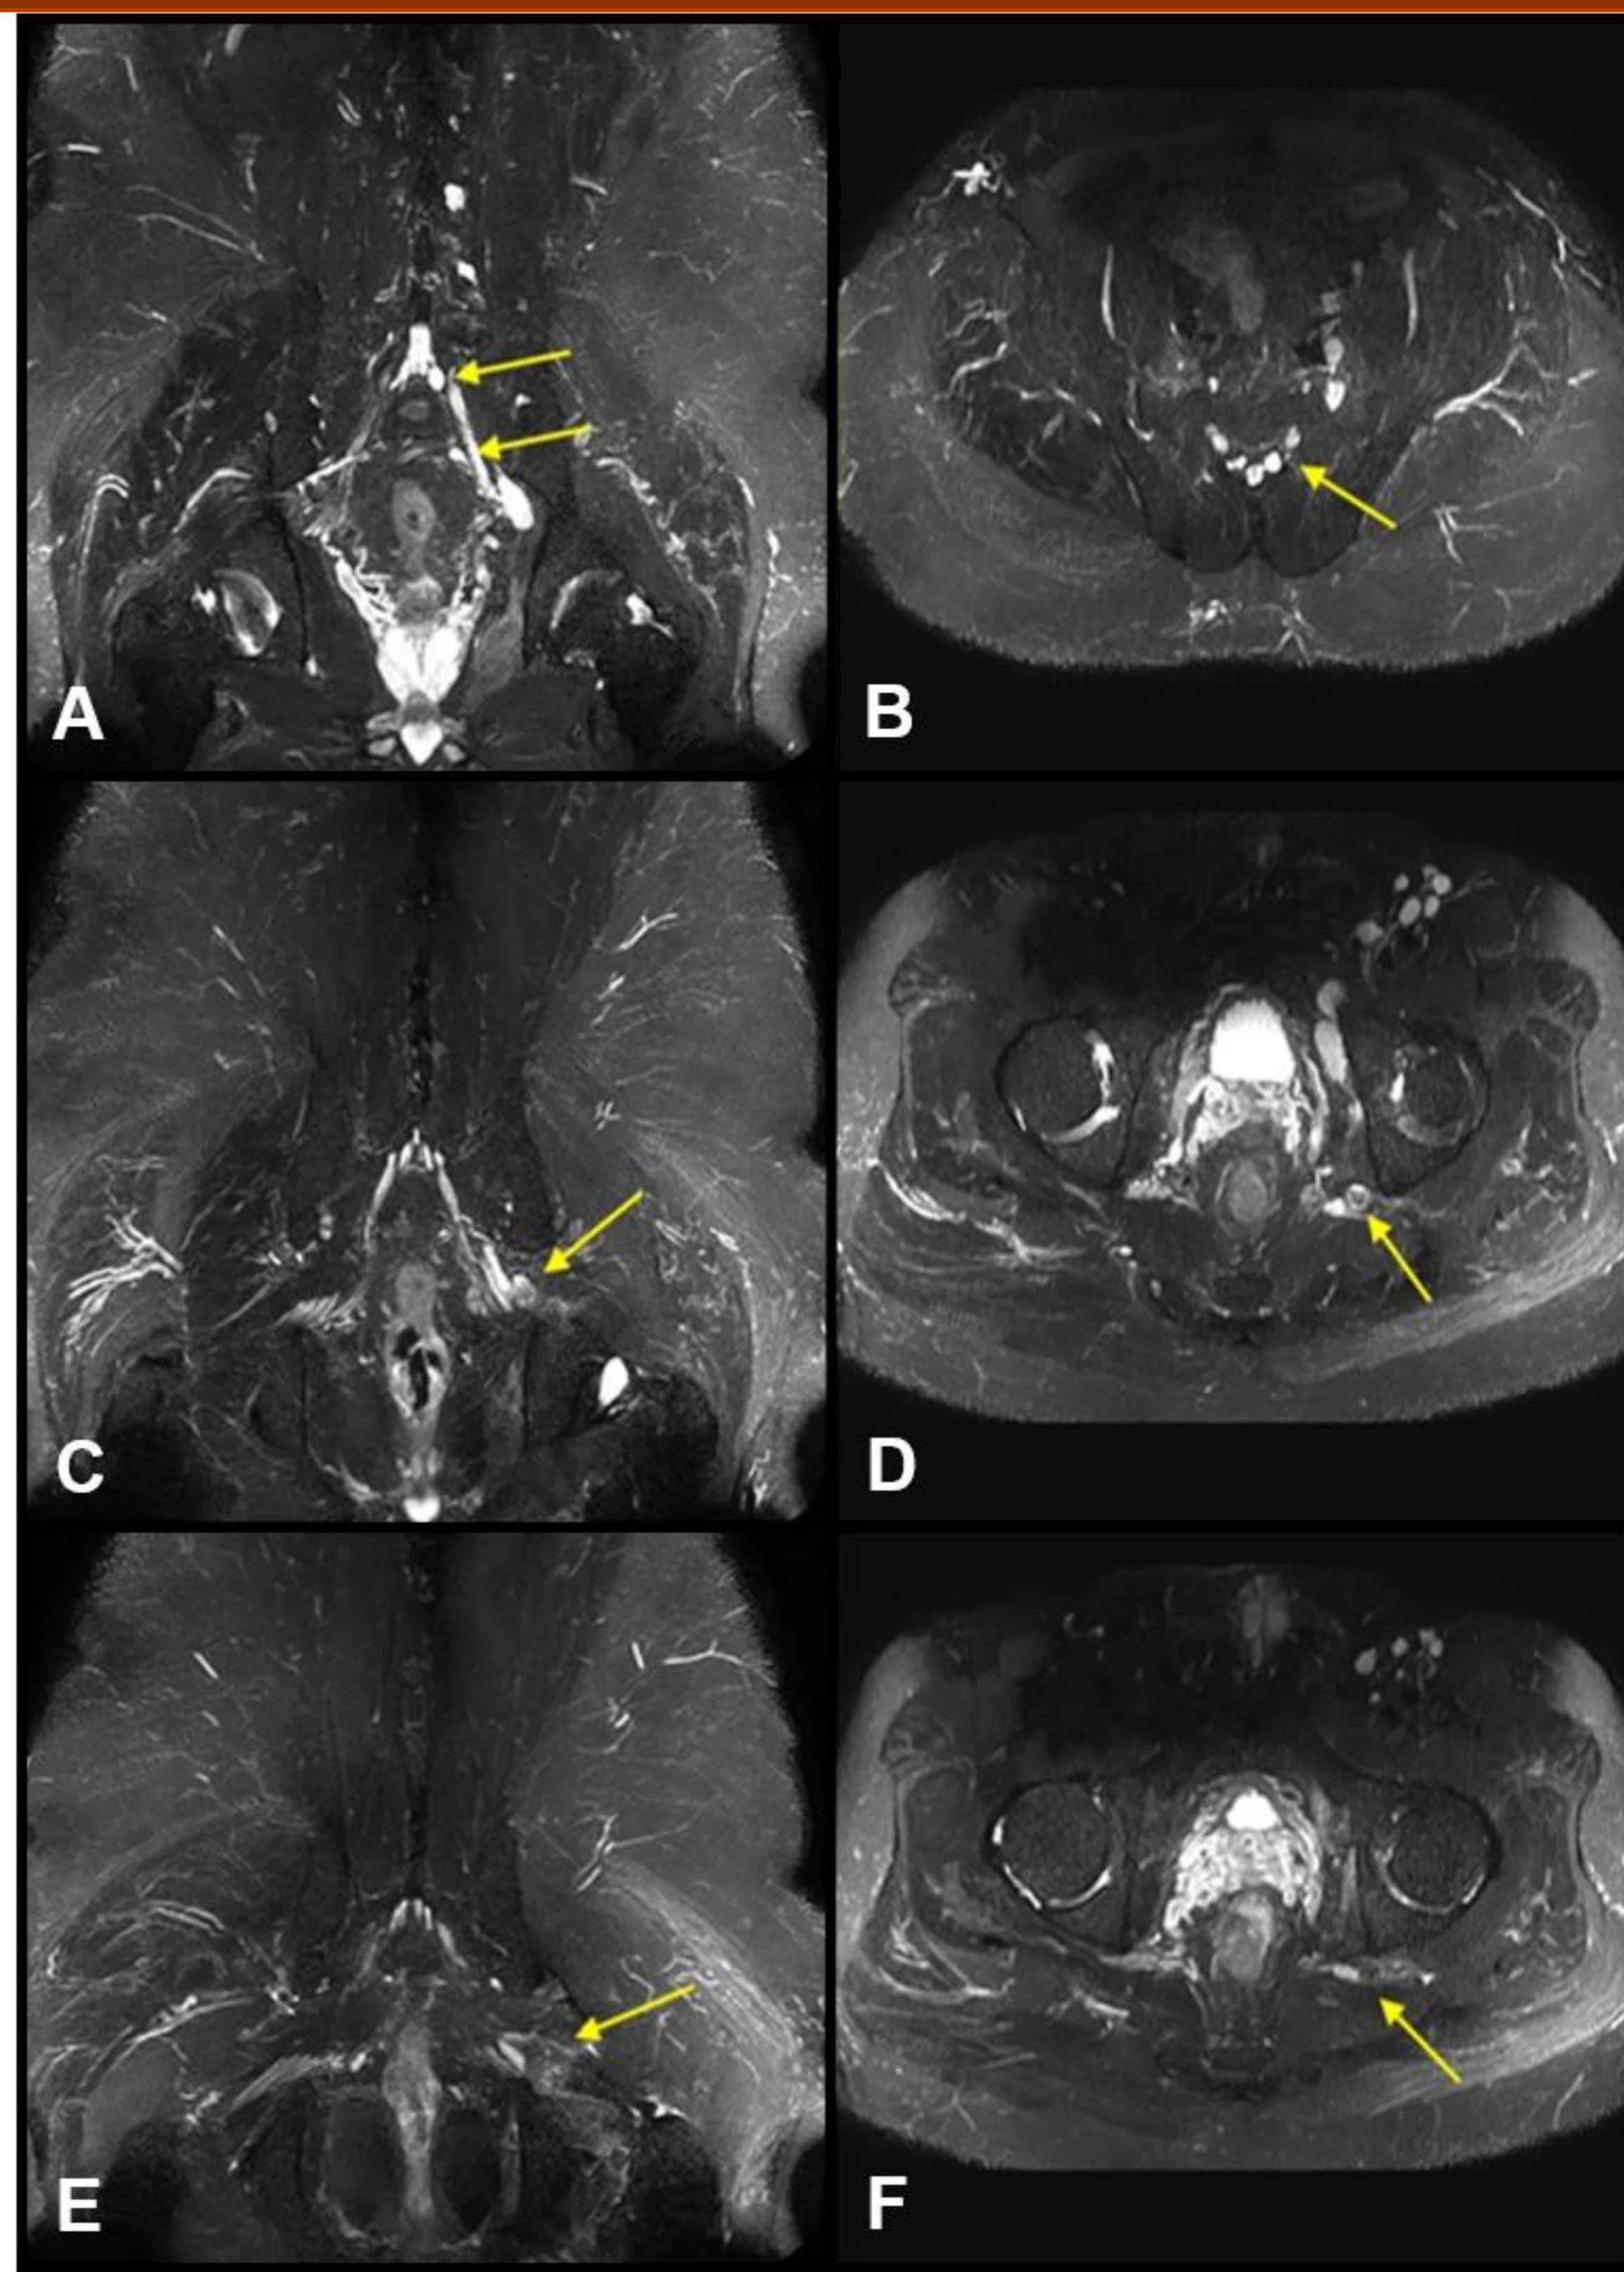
MRI demonstrates coronal and axial images of lumbar and sacral plexus. T2 hyperintensity with marked swelling of the left S1-2 nerve roots (A,B) and left proximal sciatic nerve are noted (C,D), with enhancing perineural infiltration of the sciatic nerve posterior to the posterior acetabulum (E,F), as indicated by the yellow arrows.
